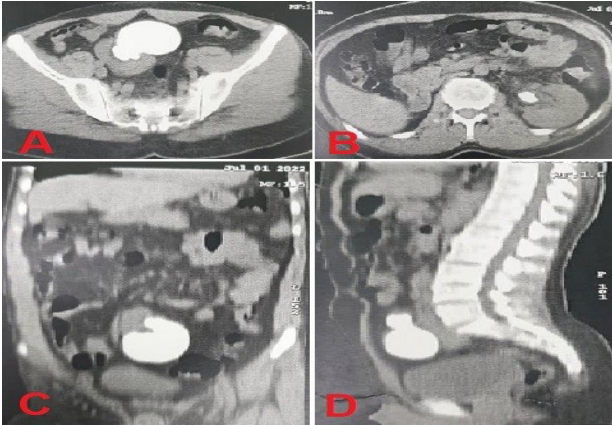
Abdominopelvic computed tomography (CT) scan without contrast. A 79 x 67 x 43-millimeter stone in right pelvic kidney (A-C-D), and a 20 x 15-millimeter stone in left renal pelvis (B)
